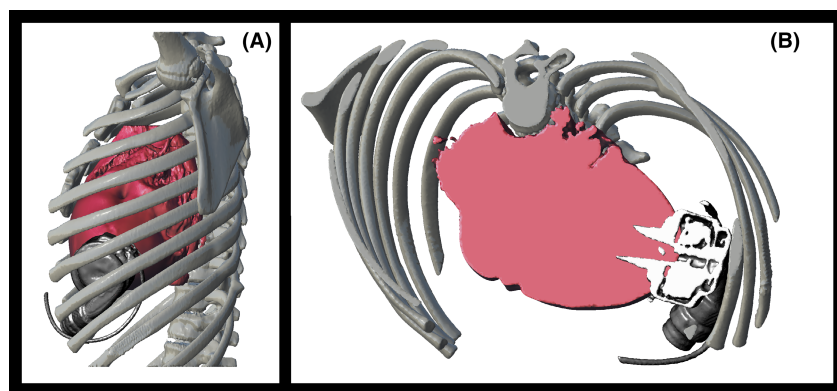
The final result of the virtual fitting of patient 9. The ribcage is confirmed as not interfering with the device (Panel A) and at the same time an oblique cut is created to test whether the pump is positioned appropriately within the heart mass (Panel B). This CT scan was acquired without a contrast medium, so a complete reconstruction of the heart chambers, such as in Figure 3, was not possible. [Color figure can be viewed at wileyonlinelibrary.com]
